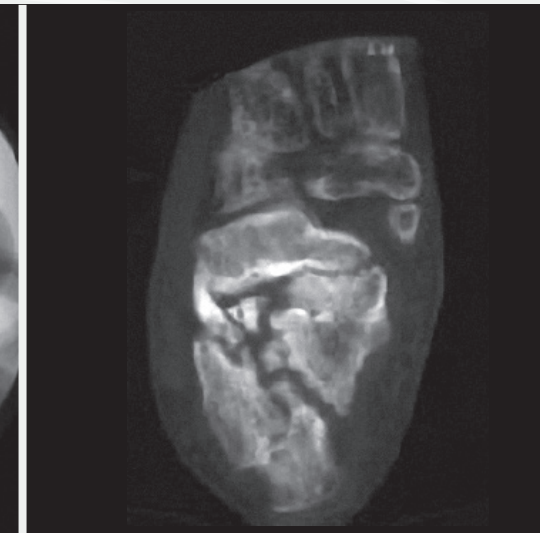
Foot CT of the initial fracture.
